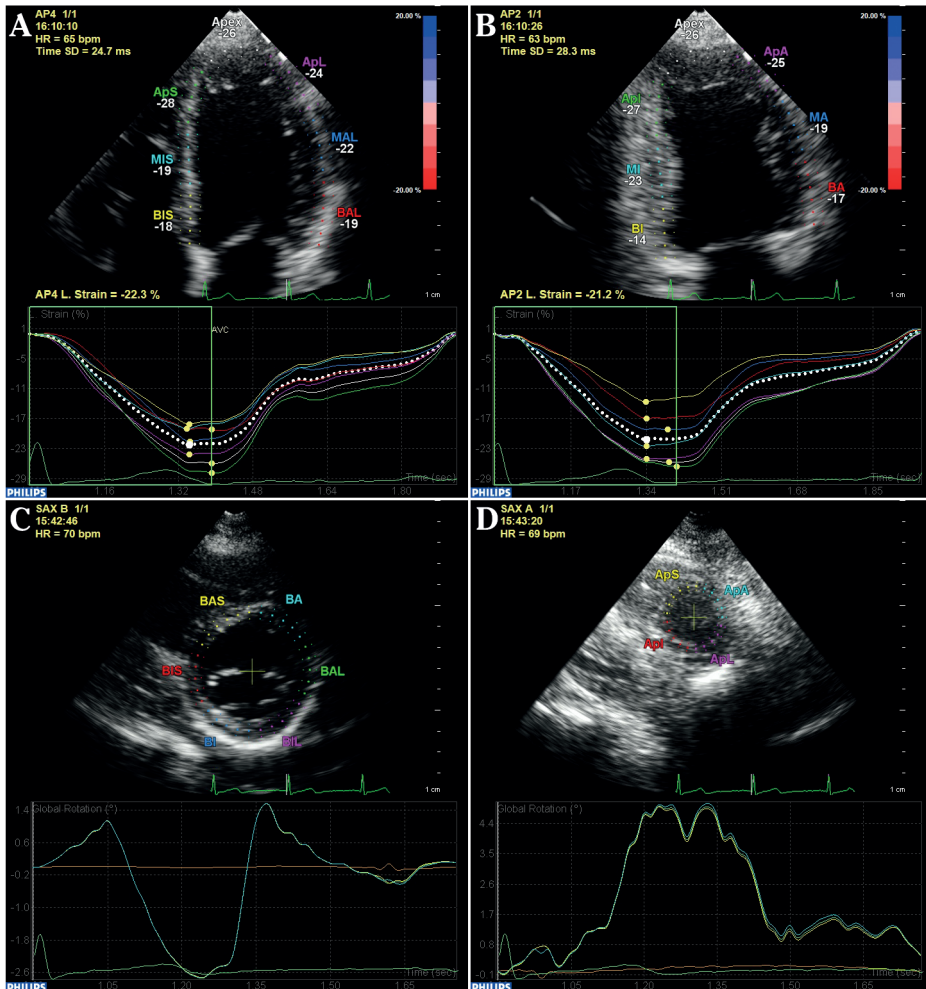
Speckle-tracking echocardiography
